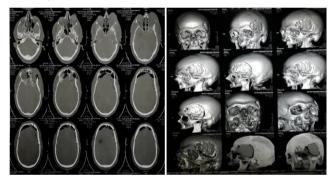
Postoperative CT brain showing tumour excision and replacement of bone by methyl methacrylate using ball and socket technique
